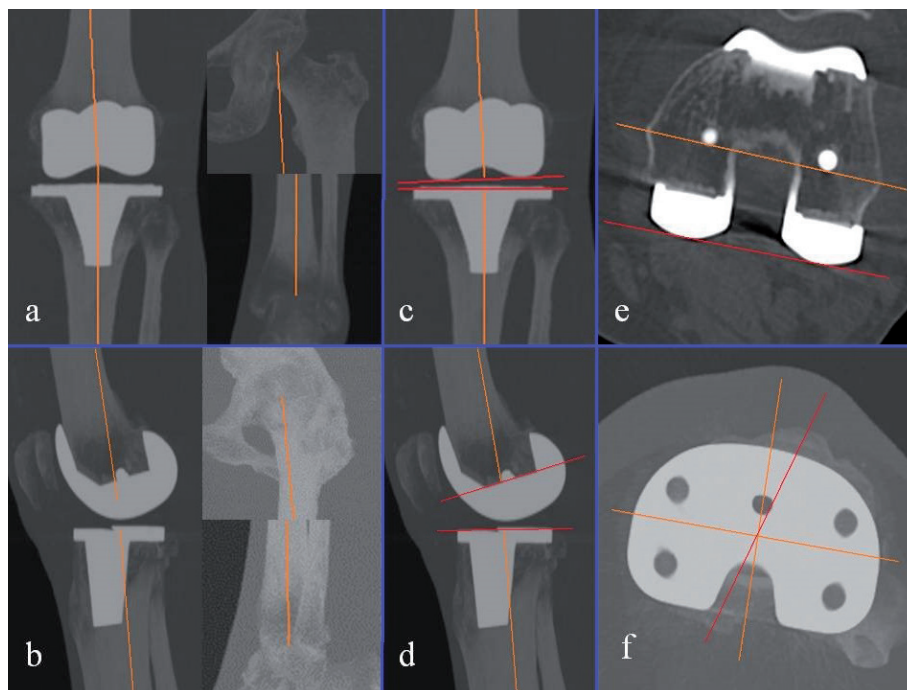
Coronal (a) and sagittal (b) MIP images of the implanted knee, hip and ankle showing the CT-derived mechanical axis for the femur and tibia, respectively. The varus-valgus deviation of the femoral and tibial components was assessed on coronal MIP images, by measuring the angle formed between each mechanical axis and a line tangent to the prosthetic femoral condyles and the tibial tray, respectively (c). The sagittal orientation of the femoral and tibial components was similarly evaluated on MIP images by calculating the angle formed between each mechanical axis and a line tangent to the distal femoral bone cut and the prosthetic tibial tray, respectively (d). The rotational alignment of the femoral component was assessed on axial images by measuring the angle formed between a line tangent to the posterior prosthetic condyles and the TEA (e). Otherwise, the axial rotation of the tibial component was evaluated on MIP images by calculating the angle formed between a line perpendicular to the maximum medio-lateral diameter of the prosthetic tibial tray and a line connecting the anterior tuberosity with the geometric centre of the tibial bone plate (f).
